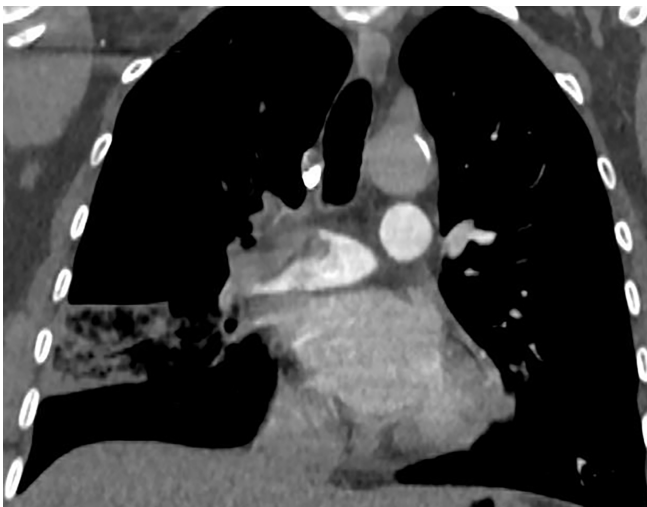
Computed tomography scan (frontal).
